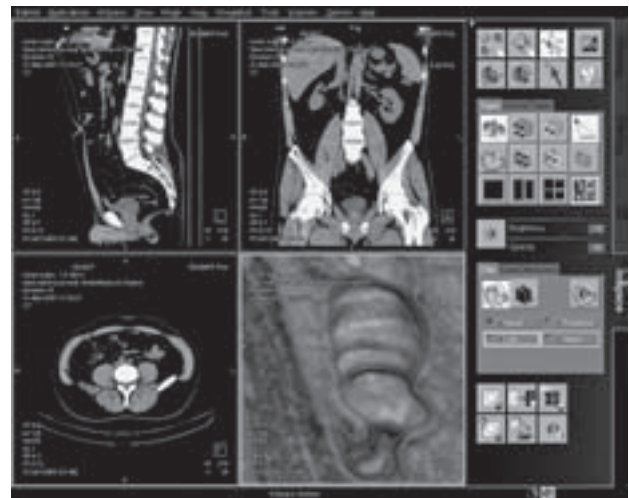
3DVR in space fly-over environment. HRCT reconstructions in three main coordinate planes were presented in the first three windows. In the fourth window, fly-over 3DVR reconstruction was performed. Part of the descendant colon was opened and functional circular stenosis due to colonic spasm was revealed. Colonic mucosa, its wall and surrounding tissue appearance around the colon was normal and without a sign of tumor.
